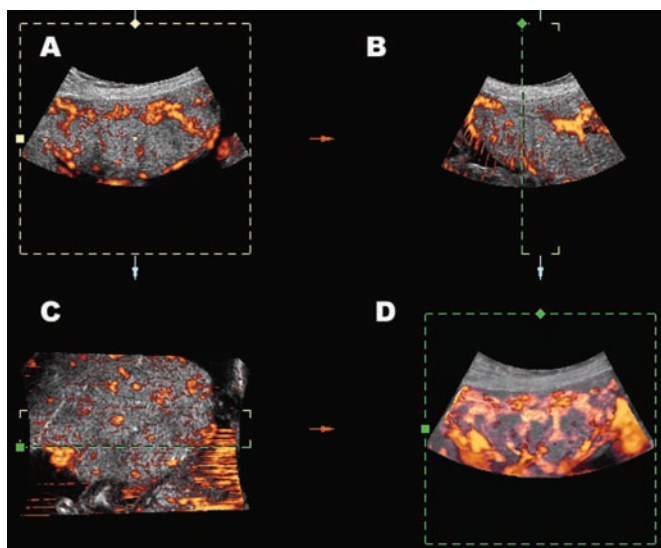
Multiplanar and rendered display of a placental volume acquired with 3D color Doppler at 20 weeks' gestation: (A) the acquisition plane, in this case along the long axis of the placenta; (B) the short axis; (C) the coronal view and (D) the 3D color Doppler and gray-scale rendered view of the placenta. Note that the rendered view represents a rather thin slice through the placenta and not the whole placental volume. The thickness of this particular volume can be judged and appreciated at (B), where you can see the green interrupted lines.
